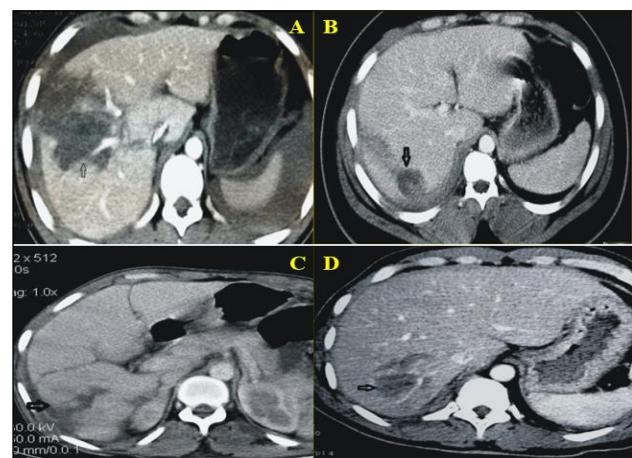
CT images showing hepatic injuries
